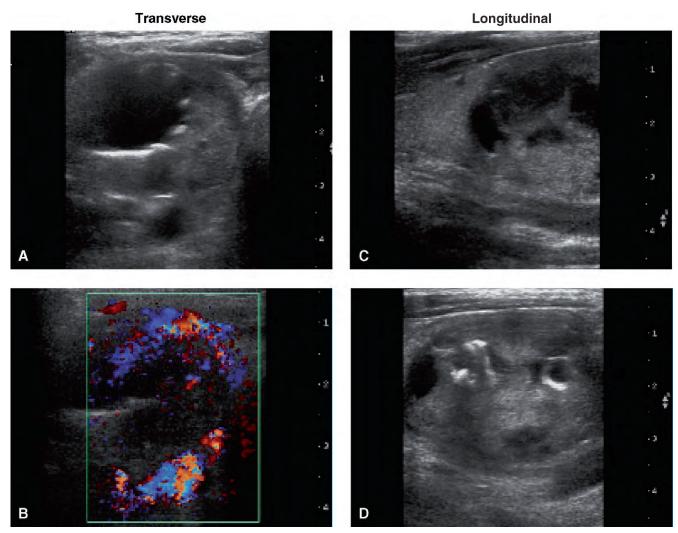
Ultrasound of a colloid nodule in the right lobe. A, Transverse, B, Color Doppler, Transverse. C and D, Longitudinal.
